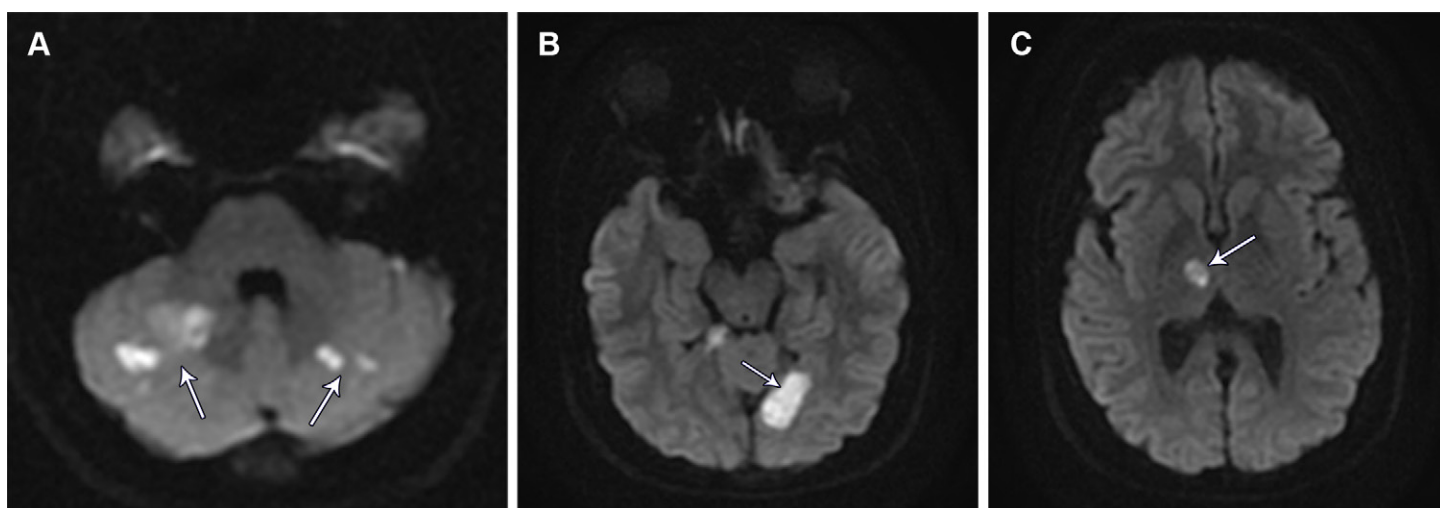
Multifocal posterior circulation infarcts due to VAD in a 17-year-old adolescent girl with DiGeorge syndrome, dizzy spells, paresthesias, and vomiting. Axial diffusion-weighted MR images from inferior to superior show multiple cerebellar (A), left occipital lobe (B), and right thalamic (C) infarcts (arrows). Multifocal isolated posterior circulation infarctions are highly suggestive of VAD.
